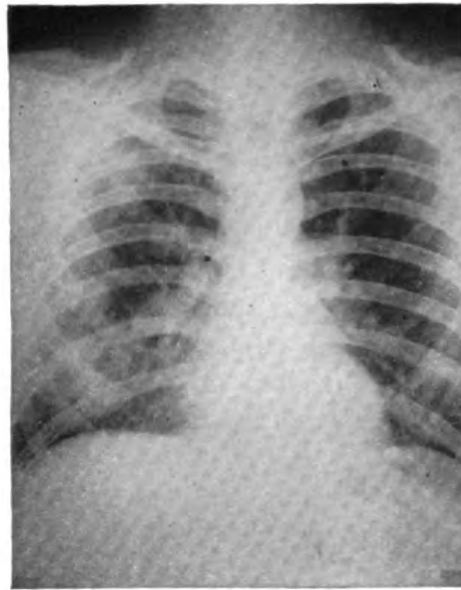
Chest roentgenogram taken 7 August 1948.
